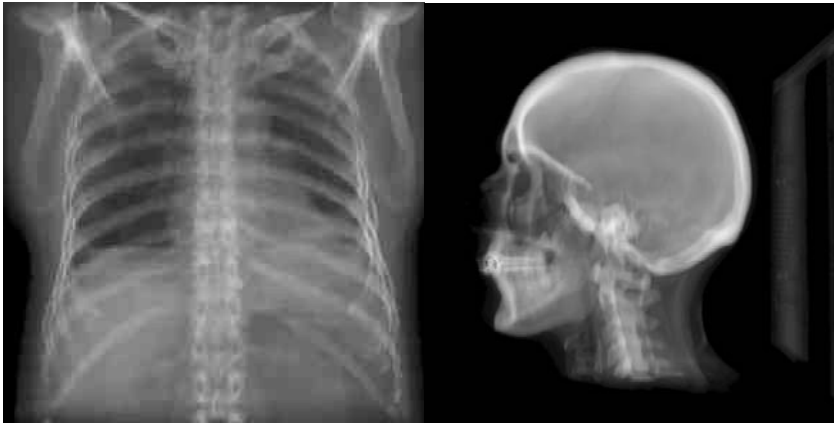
Digitally reconstructed radiography (DRR) generated from CT data sets
